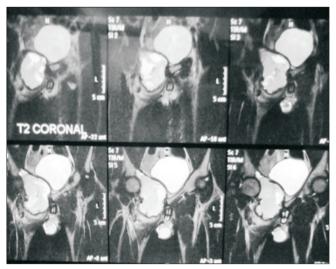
MRI showing expansile and eccentric growth from the pubic ramus.
